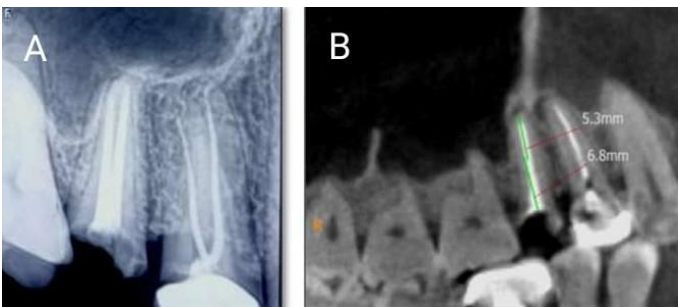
(A) - Pre operative IOPA (B) - Preoperative CBCT
